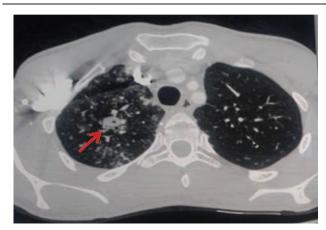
Consolidation area in the central upper region of the right lung due to a likely specific tubercular complex, associated with bilateral signs of miliary infection, more extensive to the right lung; thoracic computed tomography, axial scansion.
